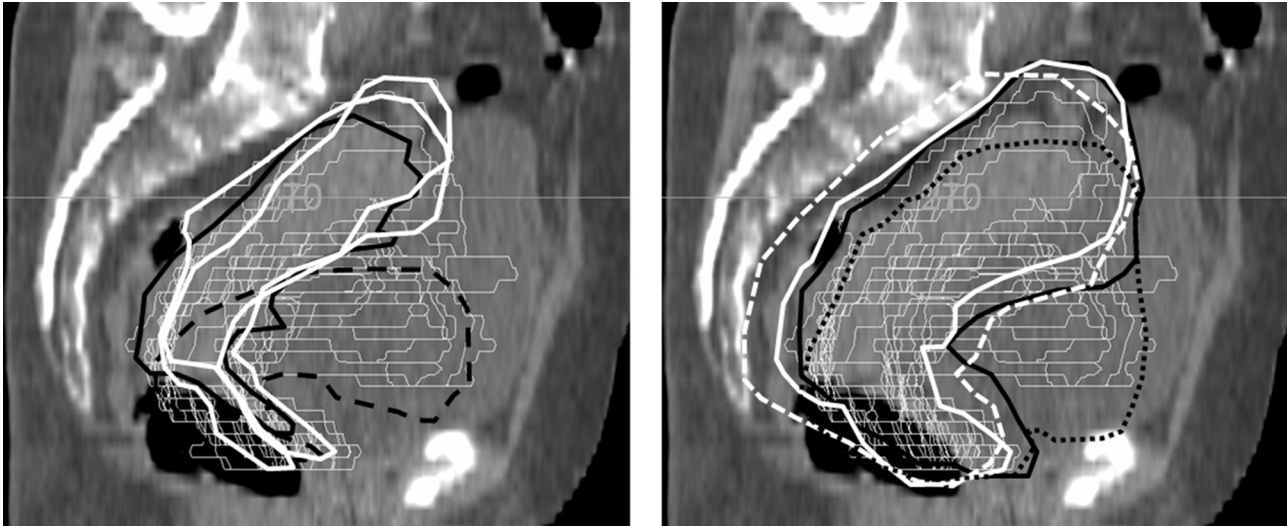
Example of the different uterus positions and corresponding PTVs. Left panel: black solid line: full bladder target position, black dashed line: empty bladder target position, white: target positions in the first week of treatment, thin grey lines: CBCT uterus positions. Right panel: black solid line: half-full-to-full PTV_{ART Library}, black dotted line: half-full-to-empty PTV_{ART Library}, white dashed line: PTV_{15mm}, white solid line: PTV_{ART ITV}.
